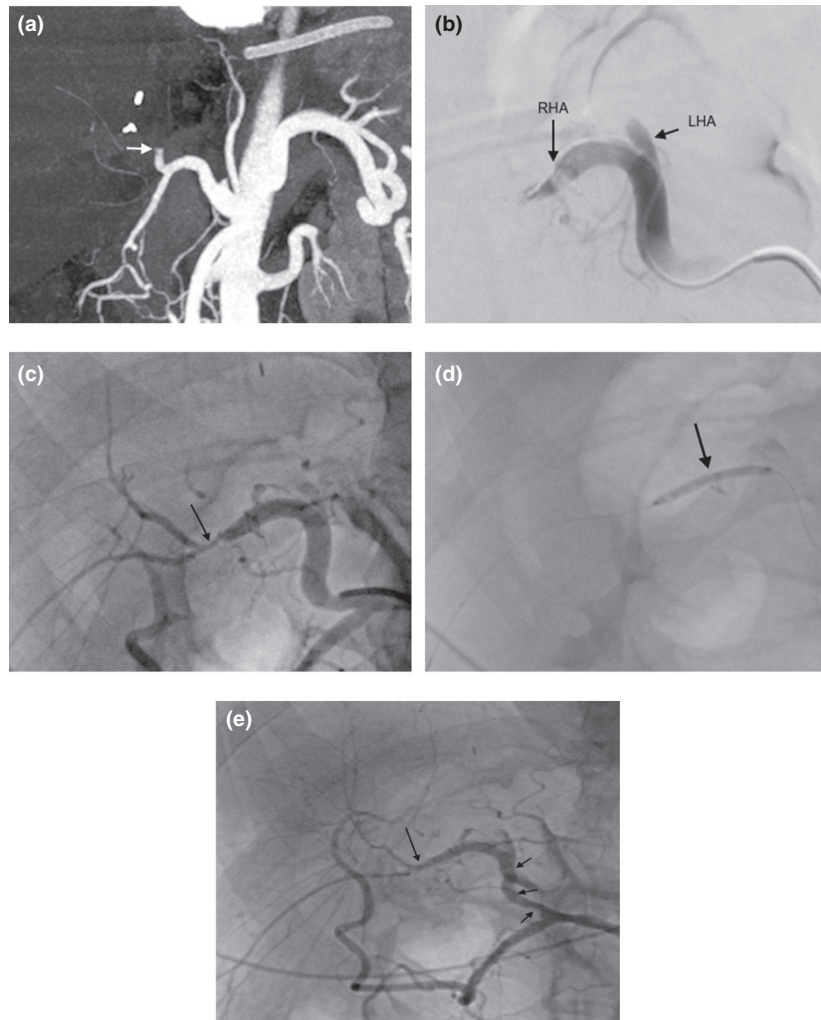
A 57-year-old LDLT recipient with mildly elevated liver enzymes and absent hepatic arterial flow on DUS on day 1 post-transplant: (a) Multi-Detector Computed Tomographic Angiography (MDCTA) image showing occlusion of the CHA (*arrow*). (b) Digital Subtraction Angiography (DSA) image, after super-selective catheterization of the RHA, showing thrombosed RHA (*long arrow*) & ligated LHA stump (*short arrow*). (c) Hepatic angiography image, after a bolus dose of 10mg tPA, showing successful thrombus re-canalization with underlying short segment stricture (*arrow*) and size mismatch between the recipient RHA & the graft artery (4.5mm/1.8 mm). (d) Image taken during balloon dilatation of the stricture up to 2mm. (e) Hepatic angiography image showing good flow in the RHA and across the arterial anastomosis (*long arrow*); note residual spasm in the CHA (*short arrows*). 'LDLT: Living-Donor Liver Transplantation; DUS: Doppler Ultrasound Scanning; CHA: Common Hepatic Artery; RHA: Right Hepatic Artery; LHA: Left Hepatic Artery; tPA: Tissue Plasminogen Activator'
